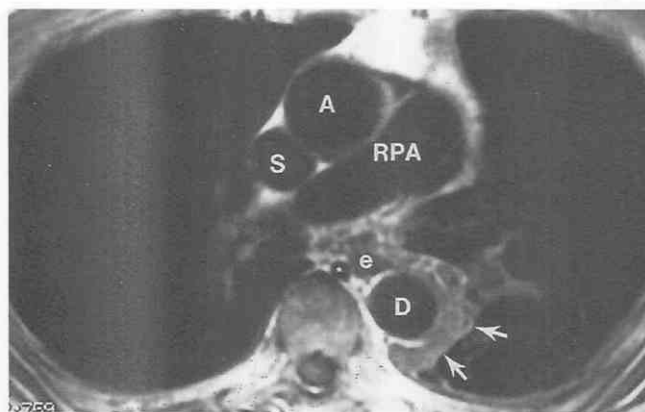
Axial MR image of the right pulmonary artery in a patient with mesothelioma of the left hemithorax. A soft tissue mass (arrows) encases the descending aorta. A, ascending aorta; D, descending aorta; e, esophagus; RPA, right pulmonary artery; S, superior vena cava. The asterisk indicates the azygos vein.
